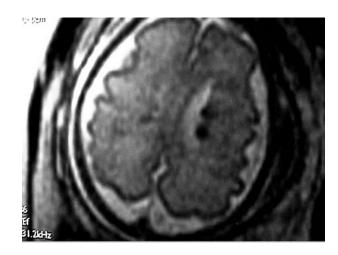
Axial fetal magnetic resonance imaging at 27 weeks of gestation showing multiple subependymal nodules and tubers.
